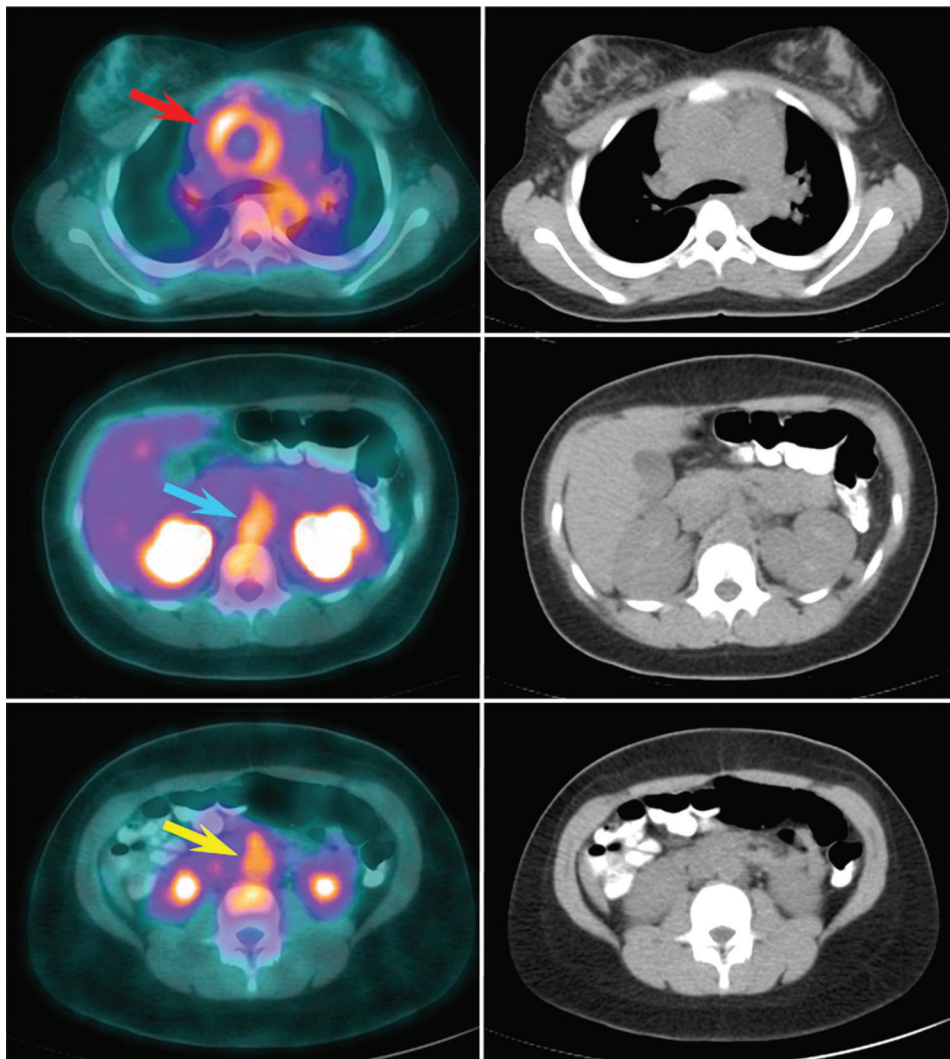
FDG PET-CT images of a patient with biopsy proven arteritis. Elevated FDG activity can be seen in the arterial wall of the aortic root (arrow red, upper panel), celiac artery (arrow blue, middle panel) and superior mesenteric artery (arrow yellow, lower panel). Left panels display fused PET-CT images, while right panels show corresponding CT slices.
